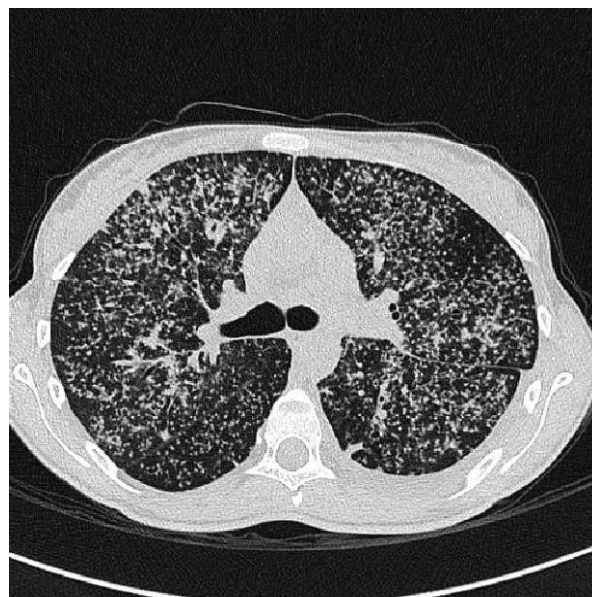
a, b : Posteroanterior chest radiograph shows multifocal masslike airspace consolidation in bilateral lung zones (a). There were wide spread micronodular hiperdens formations in whole lung in the high-resolution thorax CT (b).
